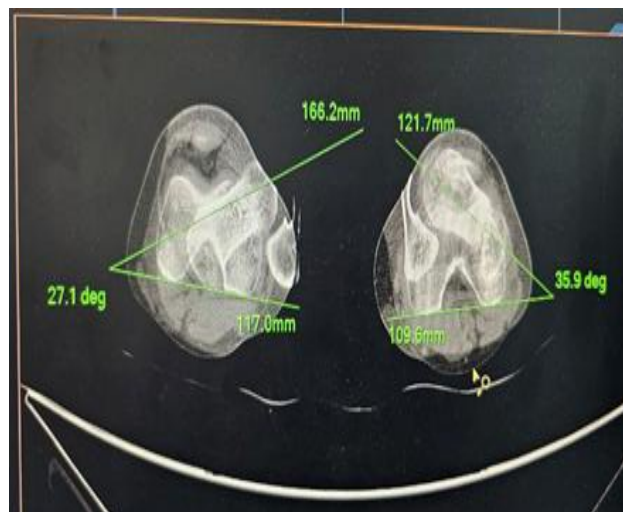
CT scan, axial view shows Femoral anteversion.
